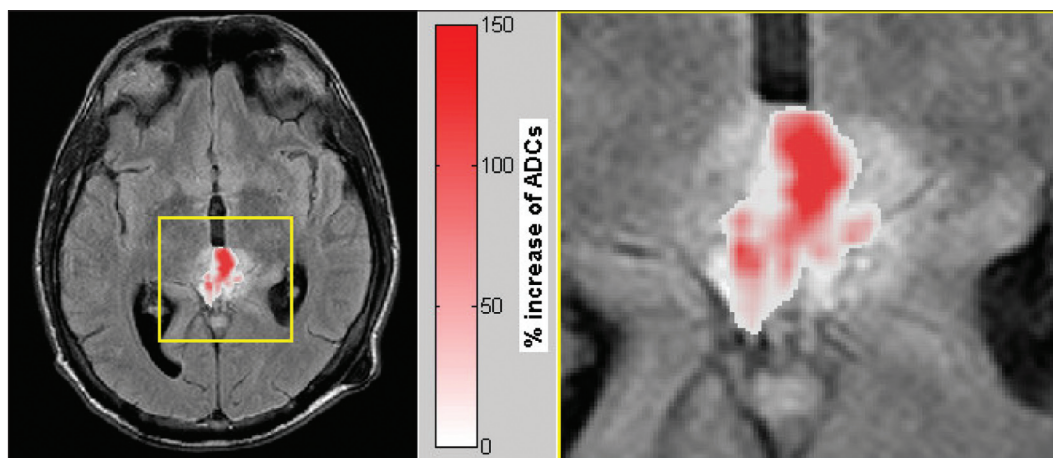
Percentual change of ADCs in necrotic area of lesion pre- and post-treatment with underlay of the corresponding FLAIR image: histogram analysis of this area yields a mean percentual increase of 67% and a maximum increase of 142% in the ADC values.
